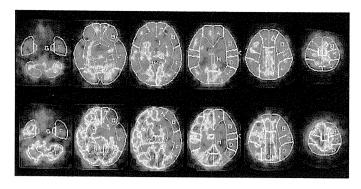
A 70-year-old man with symptomatic left ICA stenosis (90%) exhibiting MRA grade C (Fig 1). Single-photon emission CT scan shows reduction of resting cerebral blood flow (upper images) and poor acetazolamide-induced increases in perfusion (lower images) in the left MCA territory.
